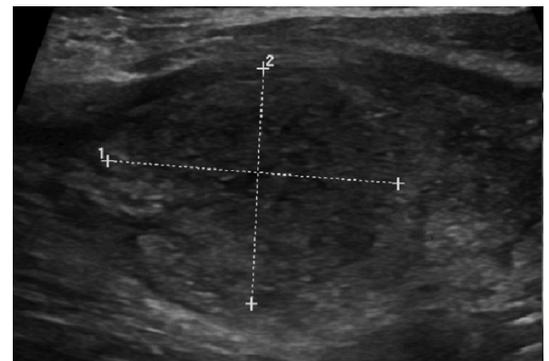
Thyroid ultrasound reveals a $2.8 \times 2.3 \text{ cm}$ hypoechoic lesion in the right thyroid isthmus.
